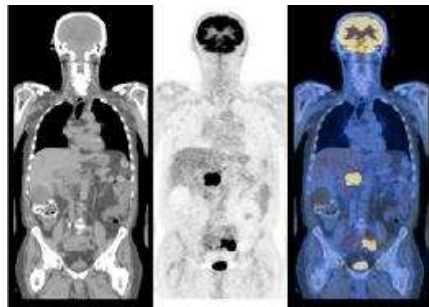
The CT, PET and fused PET/CT images.*
